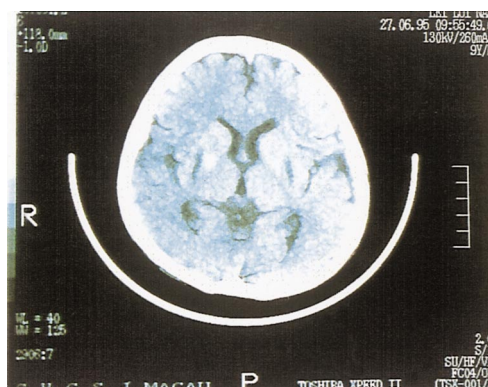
Brain CT scan in patient D.III-1 showed symmetrical and bilateral hypodensities of the lenticular nuclei.
